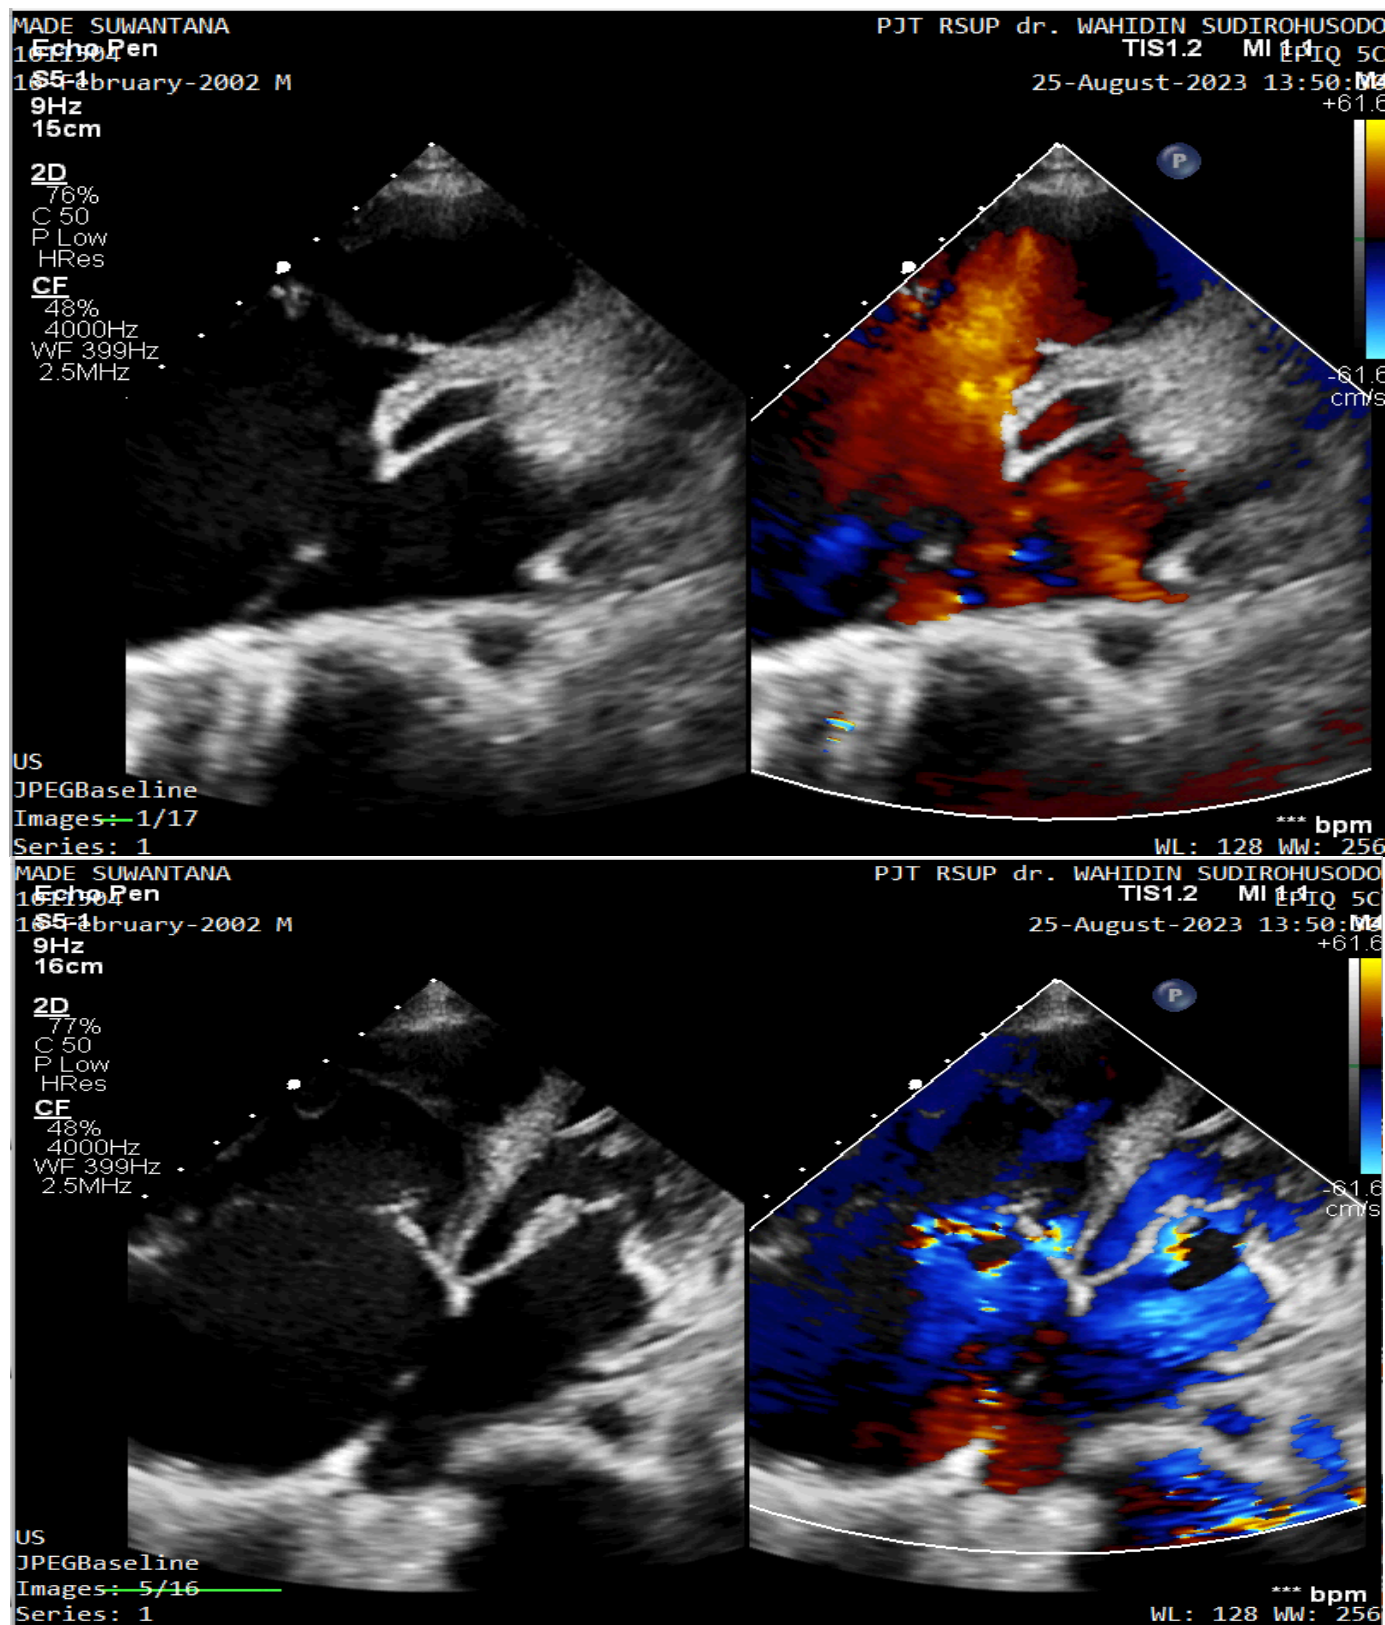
Transthoracic Echocardiography
